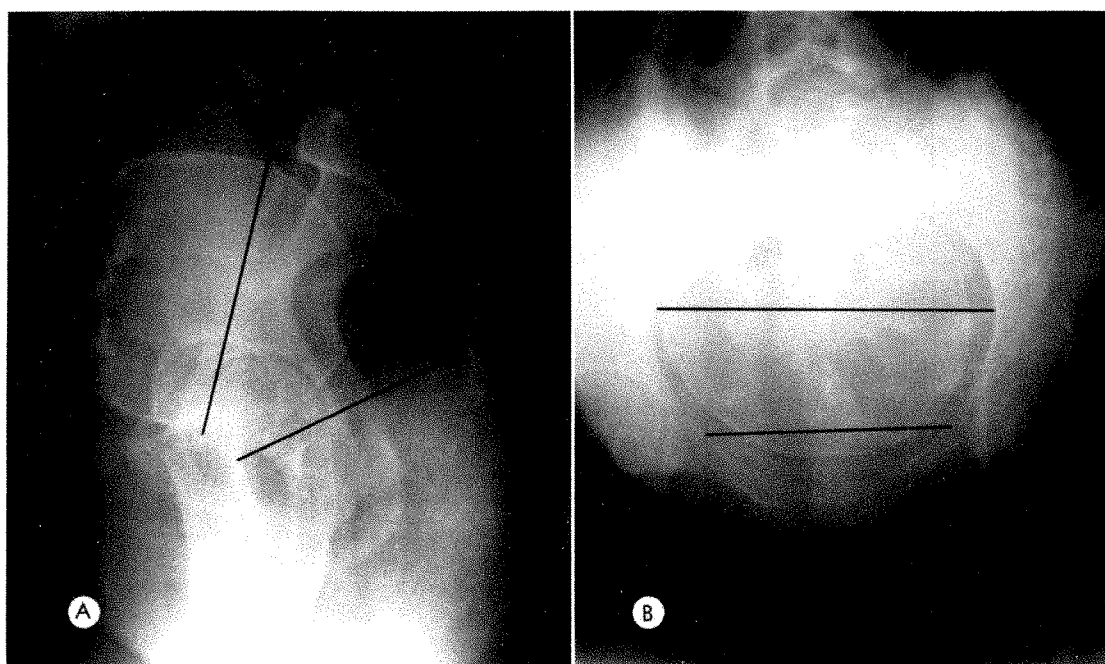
(A and B) Lateral and anteroposterior high kilovoltage pelvimetry roentgenograms demonstrate the different obstetrical diameters.
